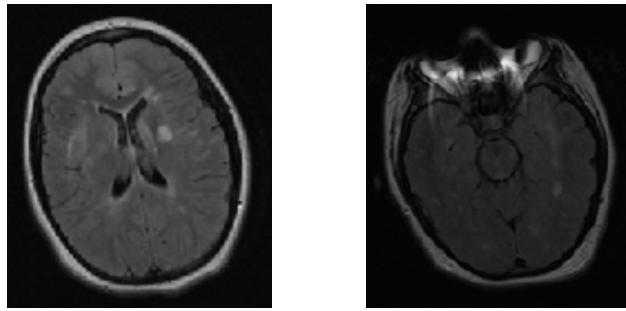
(a) Central slice of MRI scan; (b) Lower slice of MRI scan
